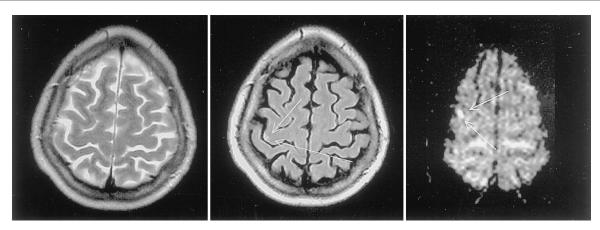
A small hyperintense area on conventional T2, flair, and diffusion-weighted MRI sequences, indicating recent vascular ischemia, is evident at the level of the prefrontal gyrus.
